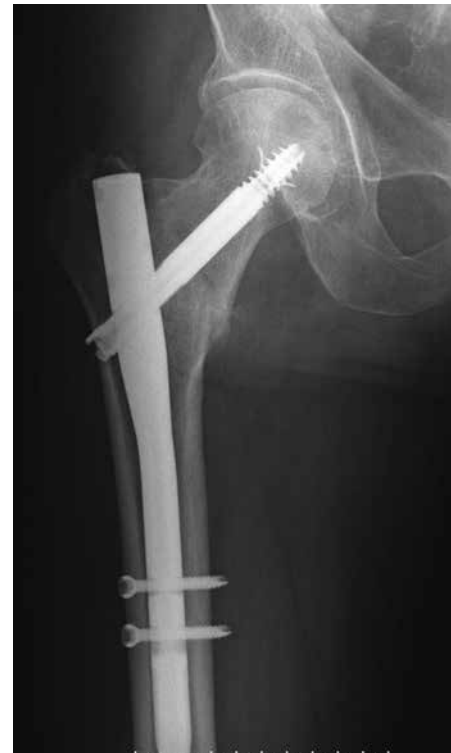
Follow-up anteroposterior radiograph of the same patient's right hip at 3 months postoperatively demonstrating the united fracture with DLT nail.
